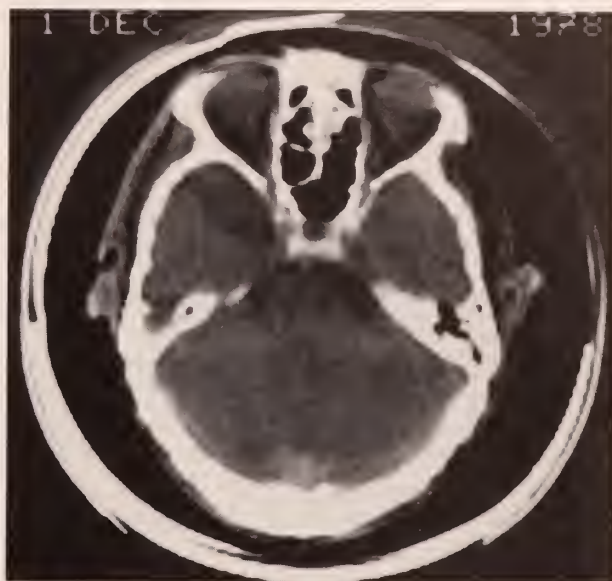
The CT scan shows lucency in the anterior left middle fossa.
